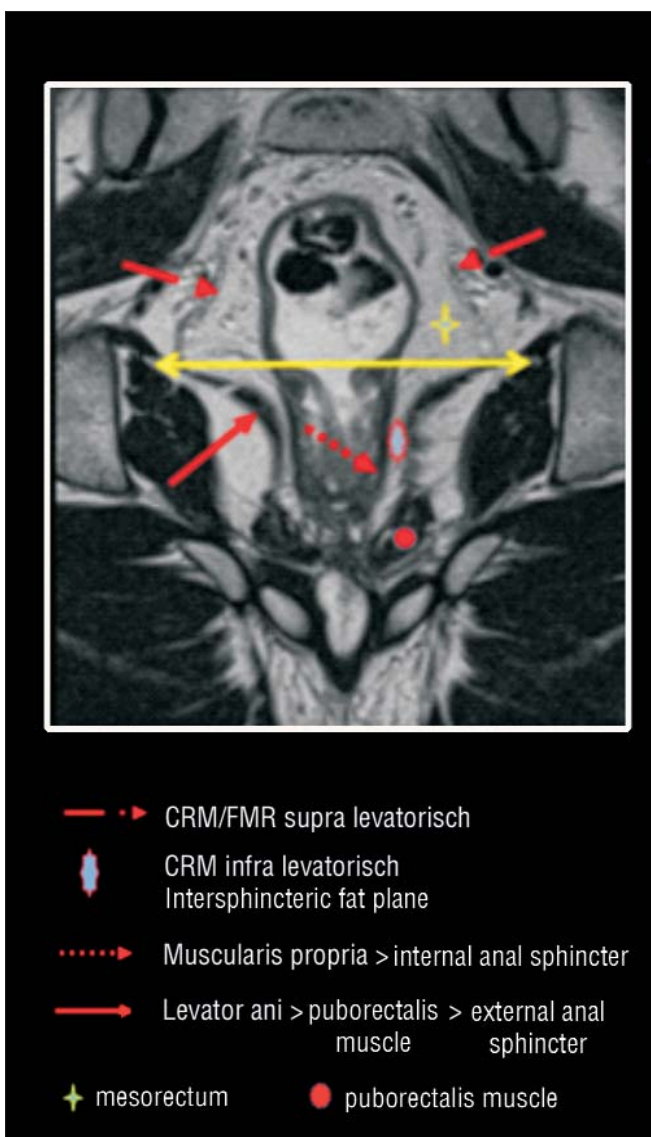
Paracoronal T2-weighted MRI: muscularis propria, the black strip, passes in the internal anal sphincter, and the anal lifter in the external canal through the puborectalis muscle. Between the black strips there is a white strip, the fat, which is in fact an extension, the end, the mesorectum stalagmite. This intersphincteric space is also very important because it has to be clear in order to perform sphincter-preserving surgery.
